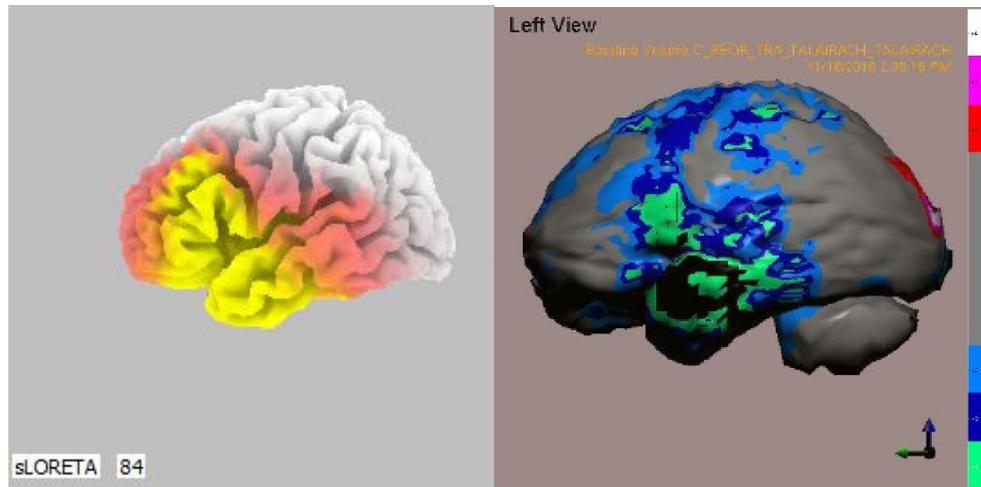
33.87Hz source localization replicates characteristic NRF ME/CFS SPECT map of diffuse vascular hypoperfusion.
